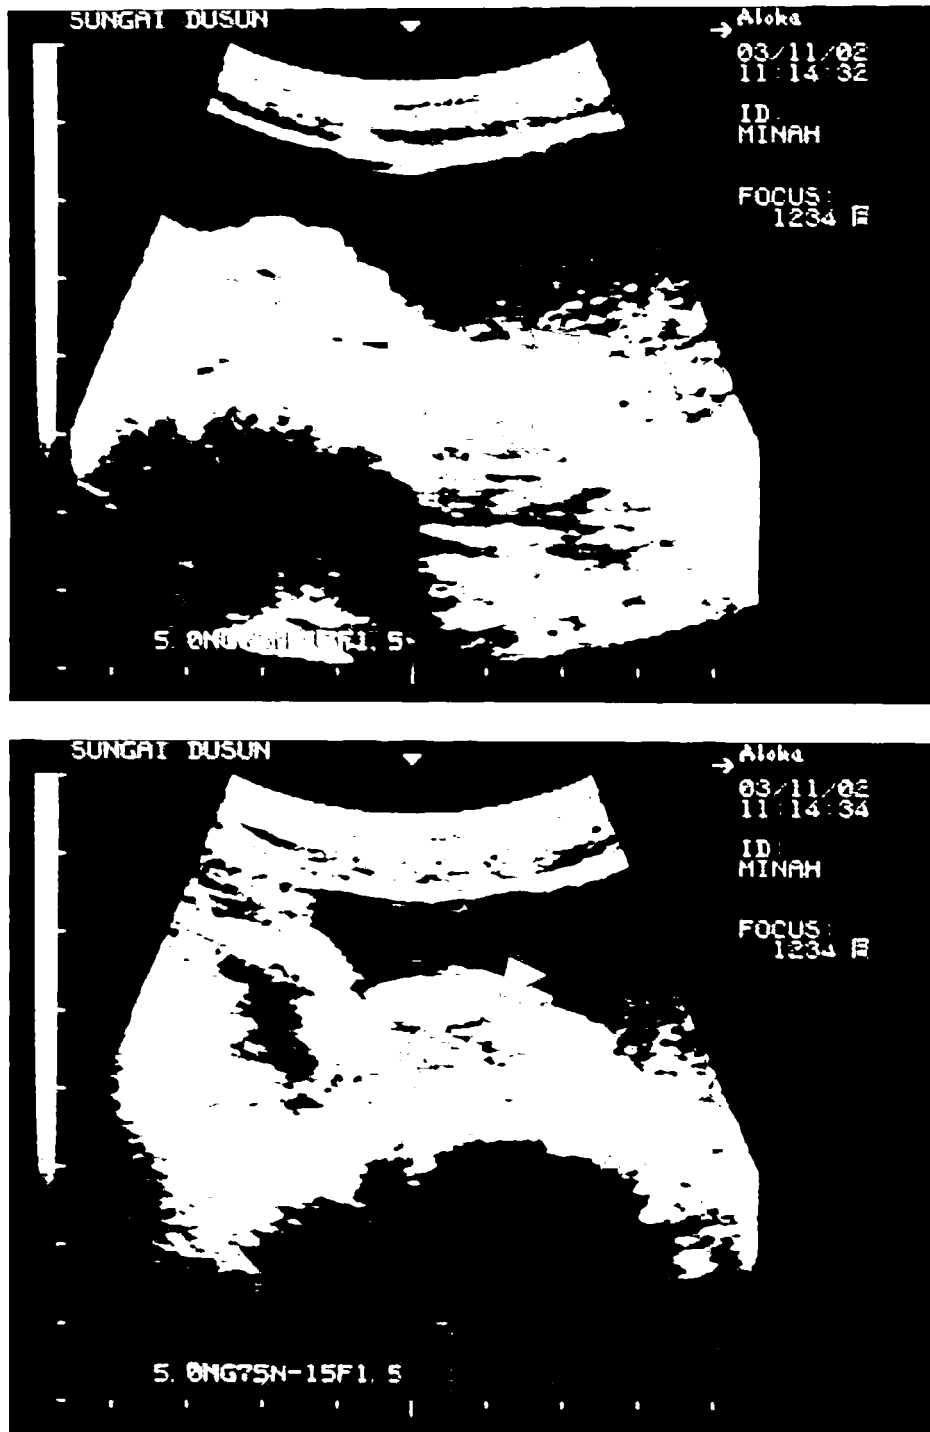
Ultrasound exam of Minah's urinary bladder 6 months following removal of CIDR implant. Normal bladder wall thickness is delineated by arrows (upper image). Note thickened area at neck of bladder which likely reflects a chronic reaction to prolonged foreign body irritation of the bladder mucosa (lower image, arrows).
